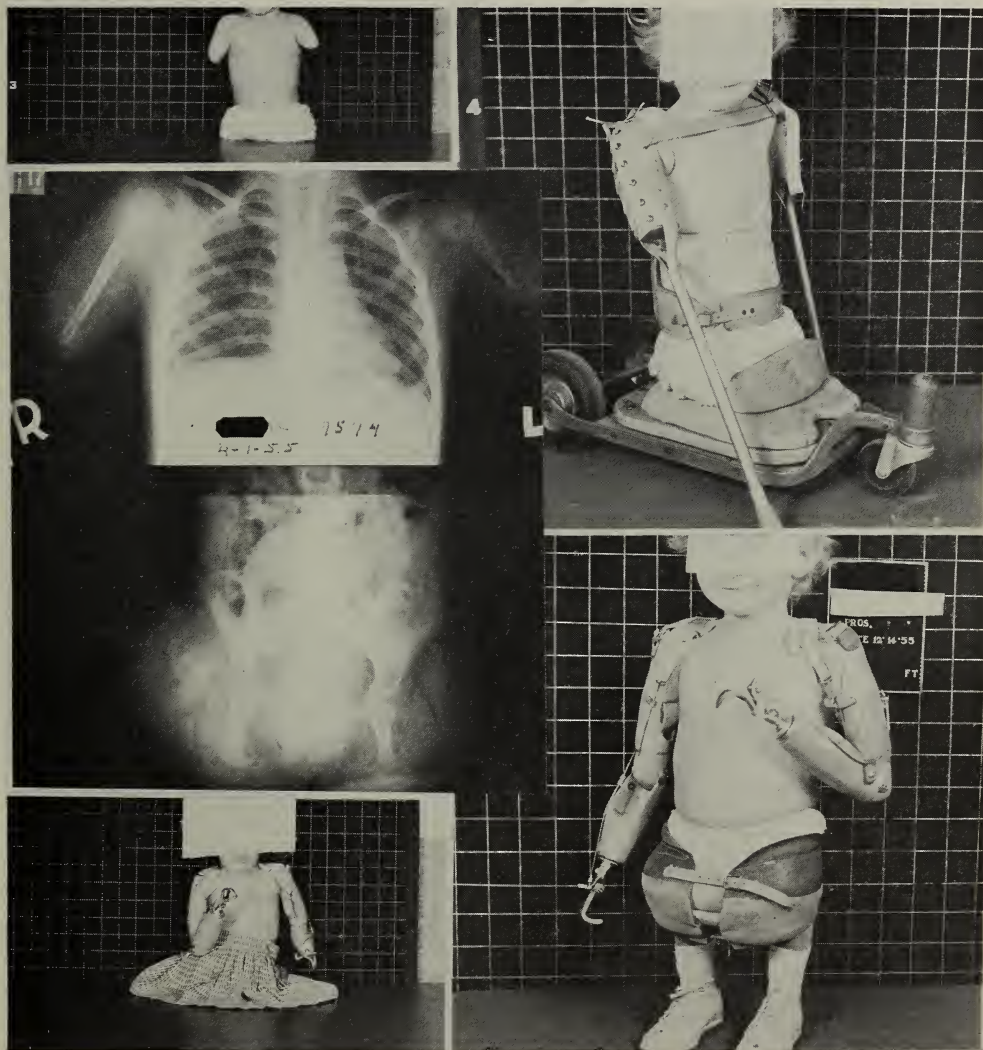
(Case 5).—*Upper left:* Statuesque torso with short upper arms and no lower extremities. *Center left:* X-ray films showing well formed upper humeral elements and no lower extremity components except right femoral epiphysis. *Upper right:* Cart and special arm pushers that aided greatly in developing muscles of shoulder girdle. *Lower left:* Wearing first standard above-elbow prostheses at 5 years. *Lower right:* Learning coordination of the upper extremities and bucket type seat with pylon legs for early "walking" and balancing.
